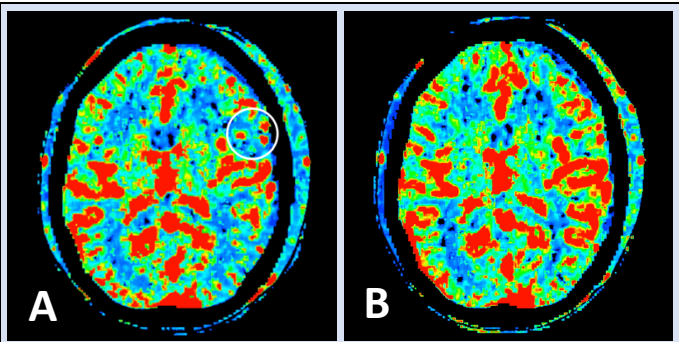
Postoperative perfusion CT findings showing A. altered cerebral blood flow in the frontotemporal region on day 5 (the circle emphasizes the most severe frontal region insufficiency) 5; B. complete resolution on day 9.
